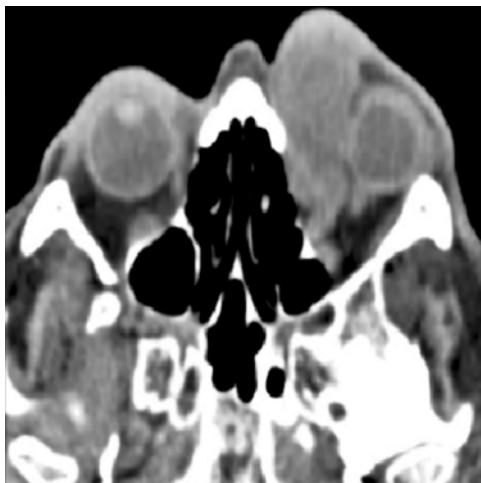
Axial CT scan image showing a large lobulated, solid extraconal mass in the medial part of the left orbit extending posteriorly up to the apex. The mass measured 47mm x 29mm. The mass was homogenous with no significant enhancement post contrast.
